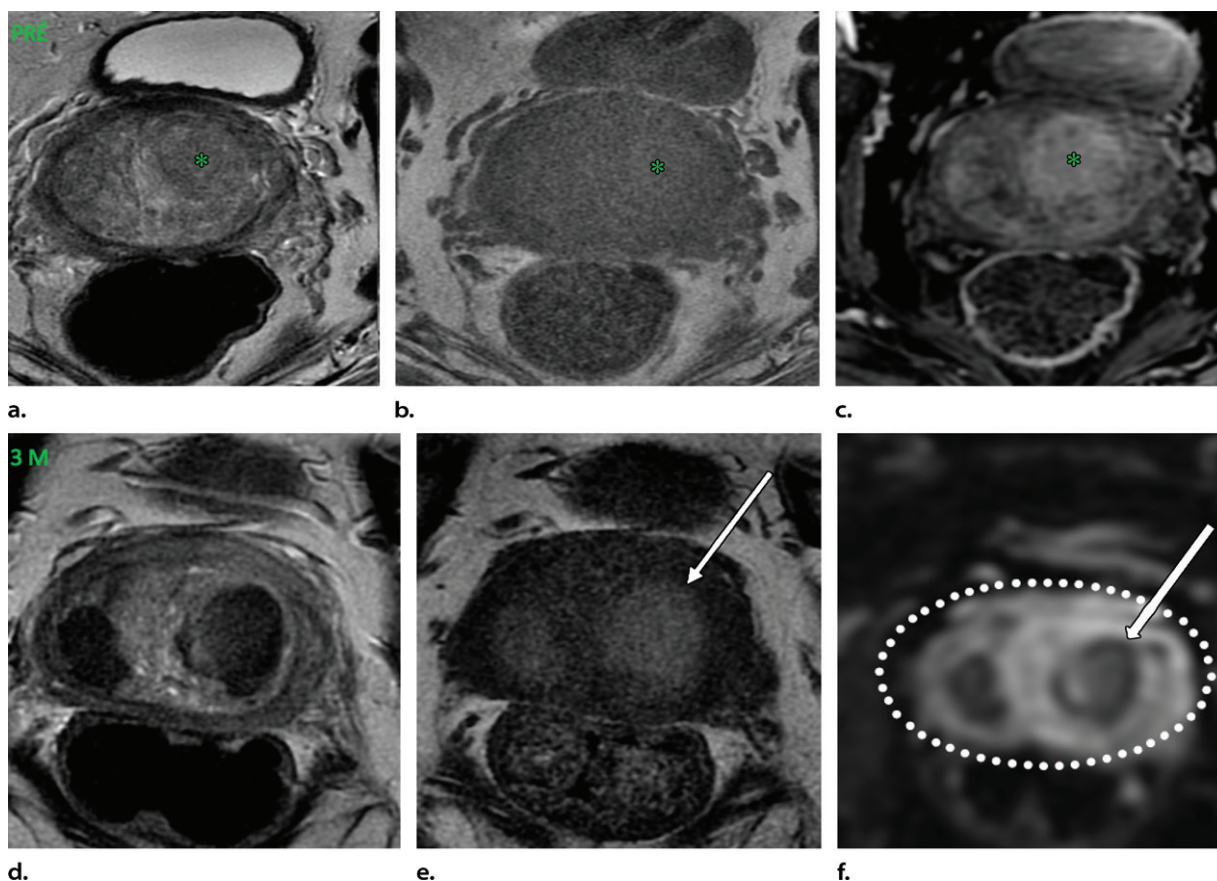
(a–c) Pre-PAE images in a 74-year-old man. Axial T2-weighted (a), T1-weighted (b), and dynamic contrast-enhanced (c) MR images show a BPH nodule with heterogeneous signal intensity (* in a), isointensity (* in b), and hyperintensity (* in c). (d–f) Axial T2-weighted (d), T1-weighted (e), and diffusion-weighted (f) MR images obtained 3 months after PAE show infarction areas in the central gland as predominant hypointensity in d, infarcts represented by new areas of hyperintensity in the central gland (arrow in e), and typical “black holes” (arrow in f). The dotted oval in f represents the whole prostate gland.
